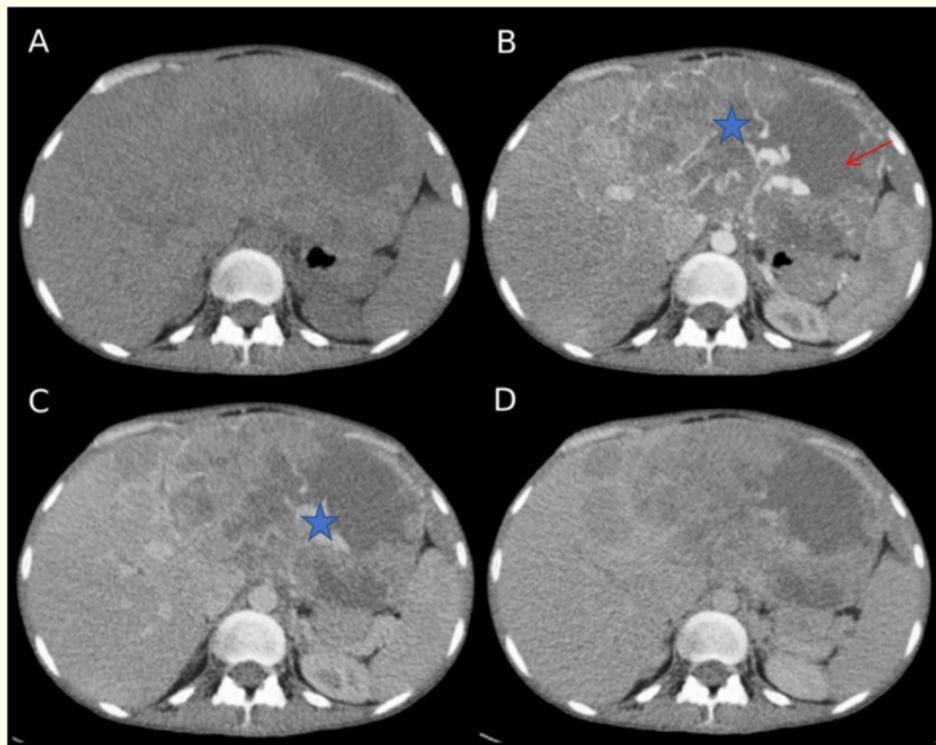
Abdominal CT, axial slices (A: without injection of contrast medium, B: C + arterial phase, C: portal phase and D: late phase at 3 min): the most voluminous hepatic masses occupied the left liver (star), oval, well limited, heterogeneous density enhanced early in arterial phase (arrow), metastatic appearance.
